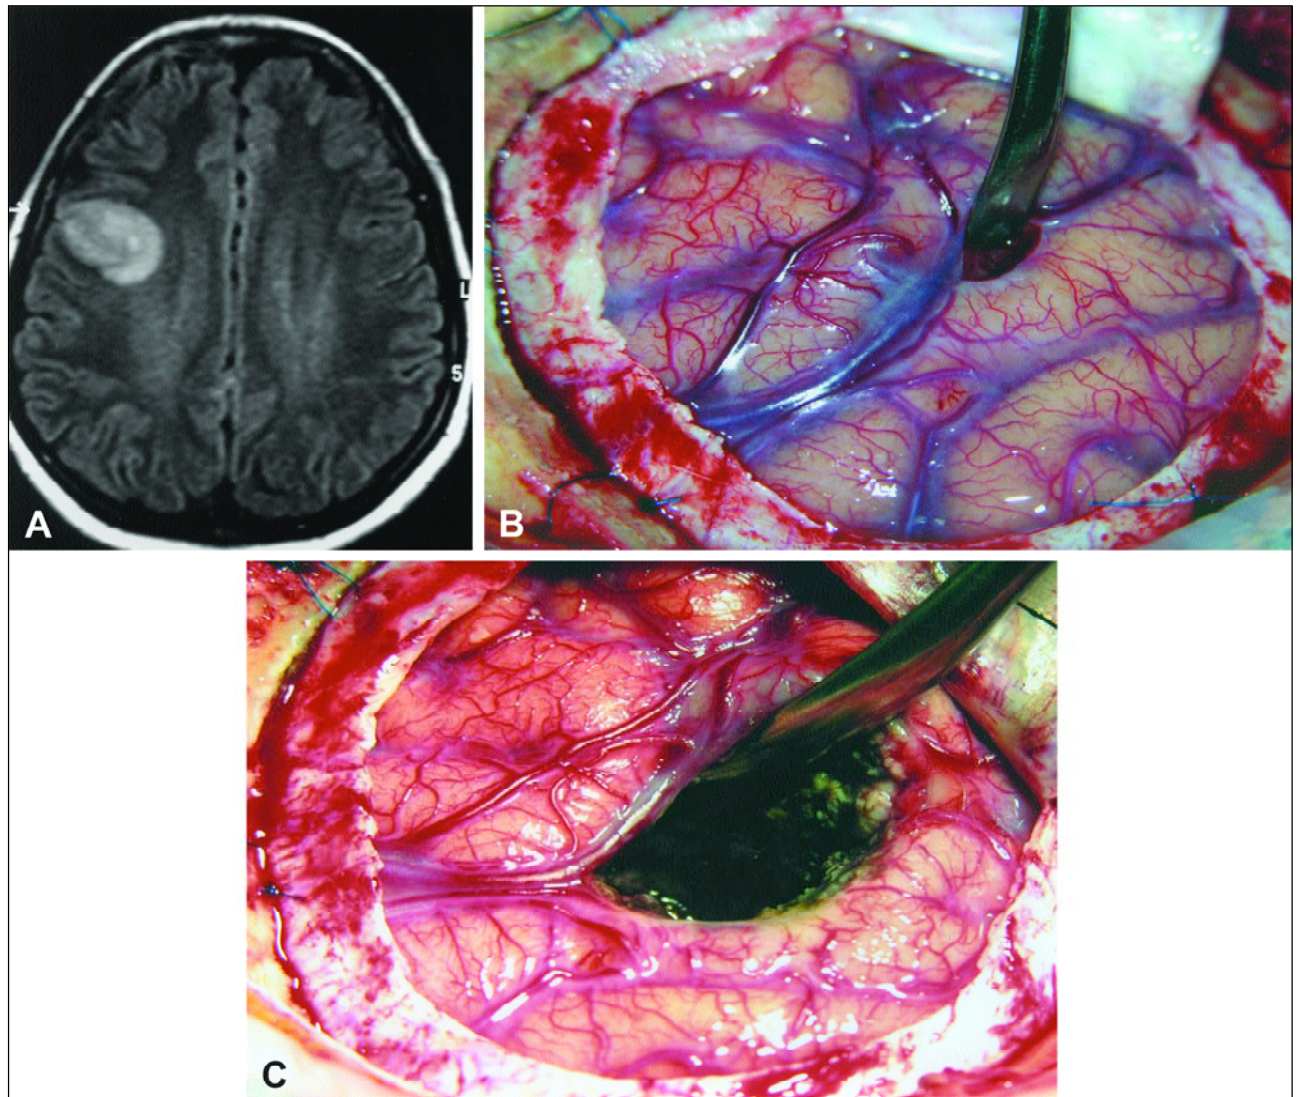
Astrocytoma grade III in a 38 years old patient. (A) MRI showing the lesion. (B) careful dissection and opening of the sulcus. (C) complete resection of the lesion with preservation of the adjacent cortex and vein.
